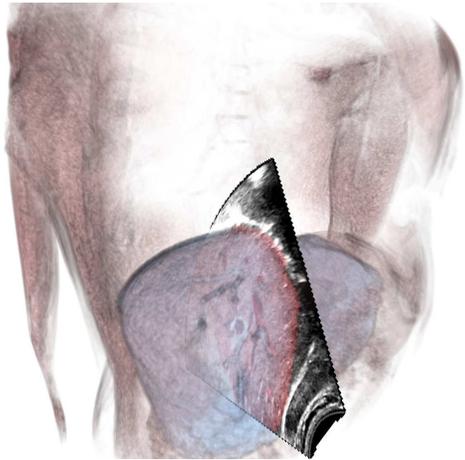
Image of a US image co-registered with the MRI volume
